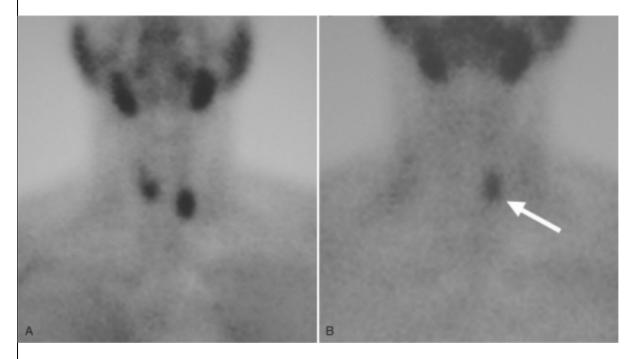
Two-dimensional planar 99Tc images showing early (A) and delayed (B) images, localizing the adenoma in the left paratracheal region. A persistent focus of radiotracer activity is evident posterior to the right inferior thyroid lobe, consistent with a parathyroid adenoma. Ultrasound or three-dimensional single photon emission computed tomography techniques can be used (not shown) to localize the adenoma in the anteroposterior direction in addition to the left or right side.
